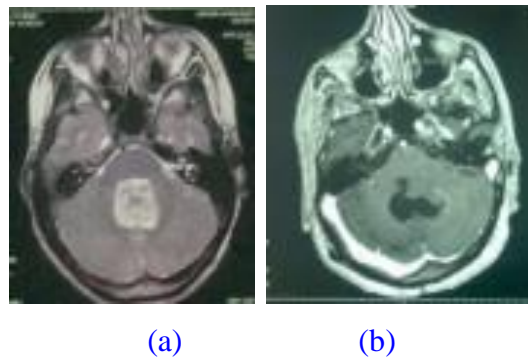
Ependymoma FCP MRI Pre (a) and post(b) operative
